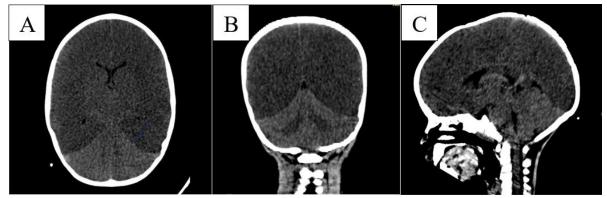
Non-contrast axial (A), coronal (B) and sagittal (C) CT scan images showing supratentorial hypodensity with deletion of sulcus and fissures in the cerebral hemispheres, associated with spontaneous hyperdensity of the thalami, brainstem and cerebellum
